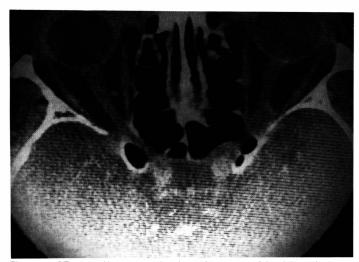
CT scan with contrast showing enlargement of the right optic nerve at the orbital apex and optic canal.
